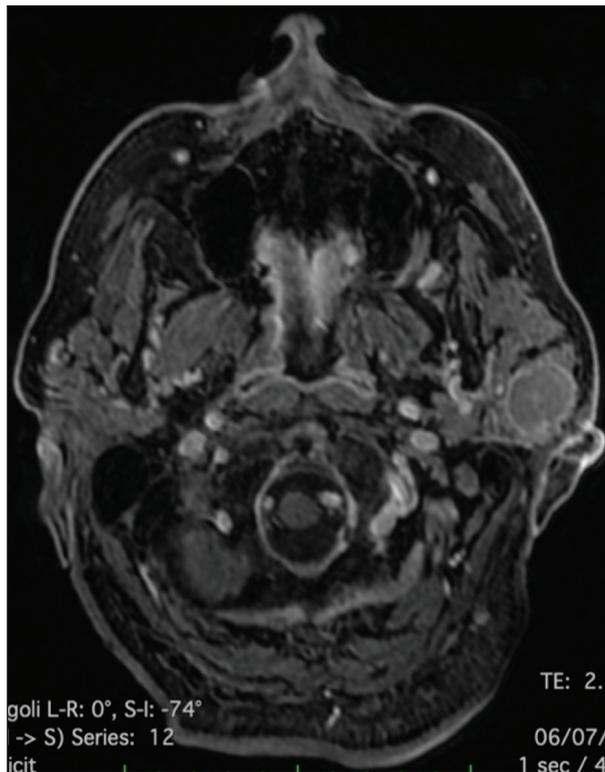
MRI with contrast enhancement show rounded nodular lesion in the context of the left parotid gland with shaded margins and peripheral enhancement.
